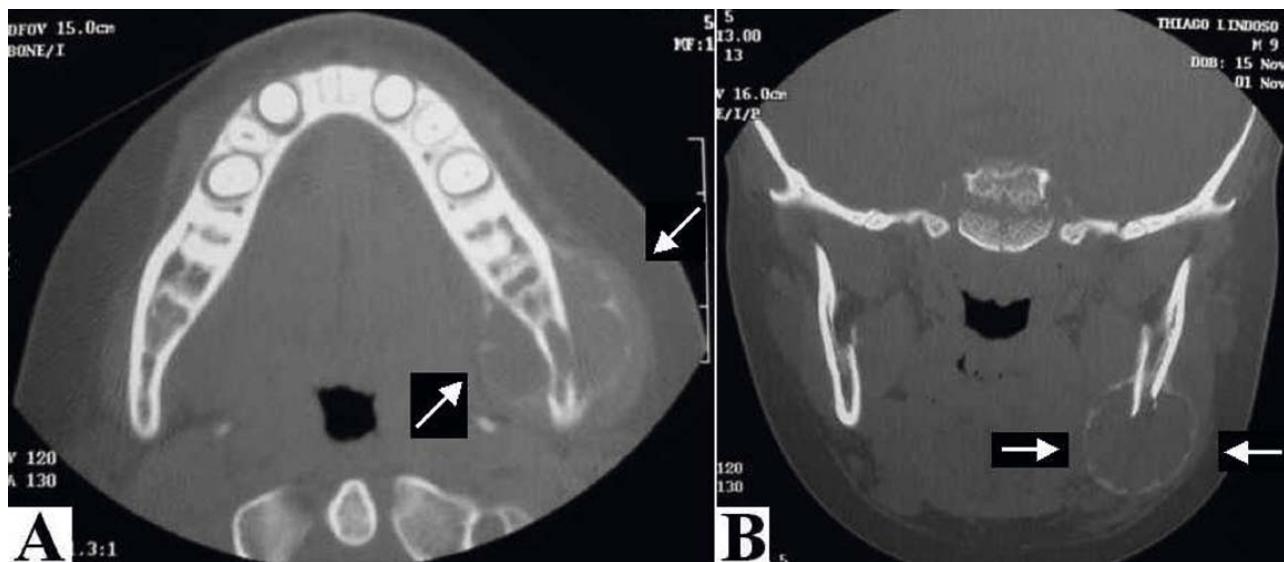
Preoperative tomographs in axial (A) and coronal cuts (B) where the type of growth and radiographic pattern of the lesion may be seen.
